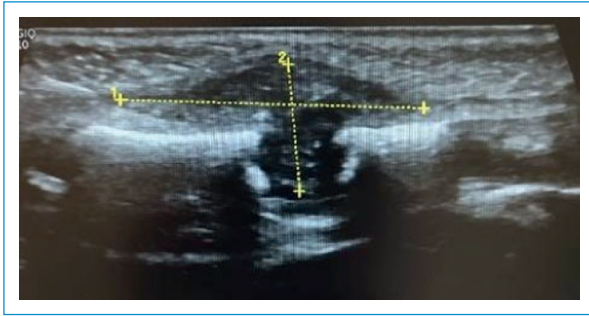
Case 1: ultrasound of sternal lesion with dumbbell-shaped subcutaneous lesion.
